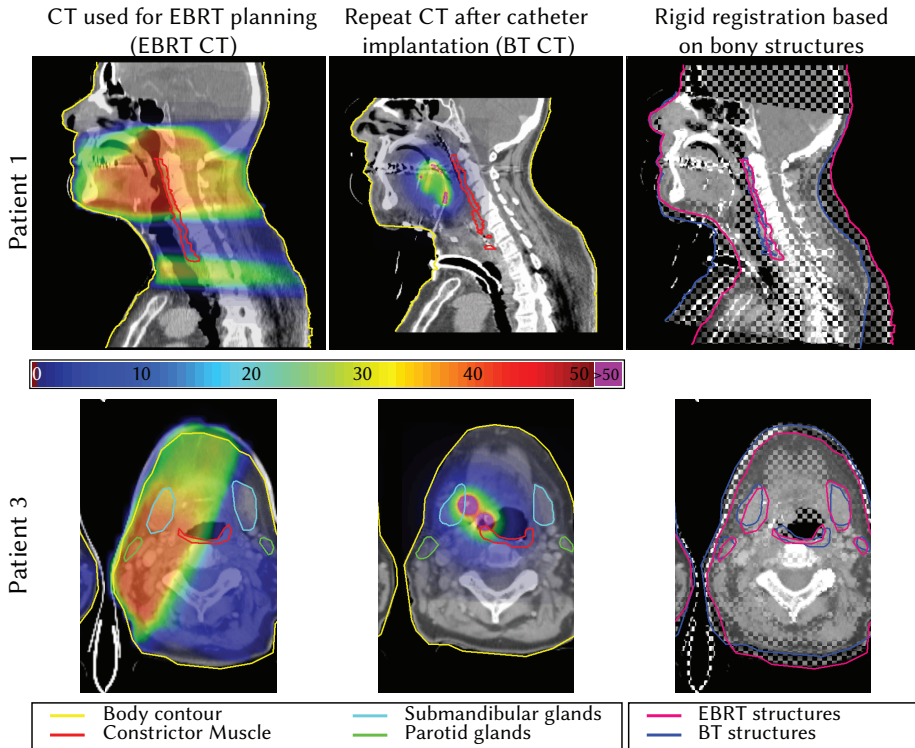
Anatomical changes between EBRT and BT for two patients. Rigid registration is not adequate to align both CT scans, as demonstrated by the last column. Large anatomical changes were caused by neck dissection, catheter insertion and different patient positioning for patient 1 (first row), and weight loss for the second patient (second row).
